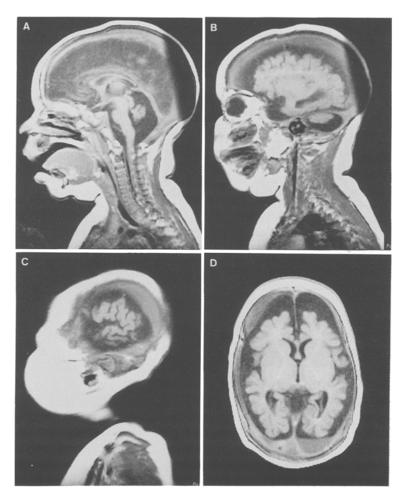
MRI of the brain at age 4 months: (A-C) sagittal; T1-weighted images; (D) transverse axial image. (A) Severe hypoplasia or atrophy of the cerebellar vermis and a relatively undeveloped pons. (B) Severe hypoplasia or atrophy of cerebellar hemisphere. (C) Lateral view of the insula, showing severe atrophy of the perisylvian cortex. Subdural haematomas, possibly due to cerebral shrinkage and overstretched bridging veins are evident in images (B), (C) and (D)
